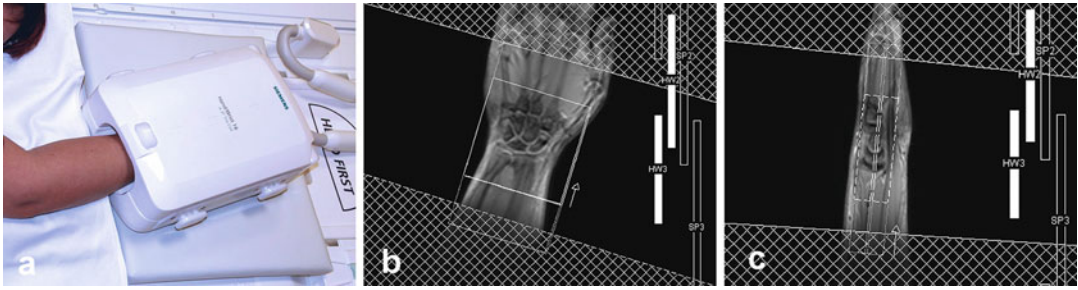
Acquisition technique of wrist MR imaging. (a) In-center positioning of the wrist. The patient is lying on the MRI table in the “superman position” (i.e., lying prone, with the arm overhead and the hand pronated). The hand is placed in a 16-channel, phased-array coil dedicated for high-resolution wrist and hand MRI. (b, c) Coronal and sagittal localizers (scouts) for planning a
